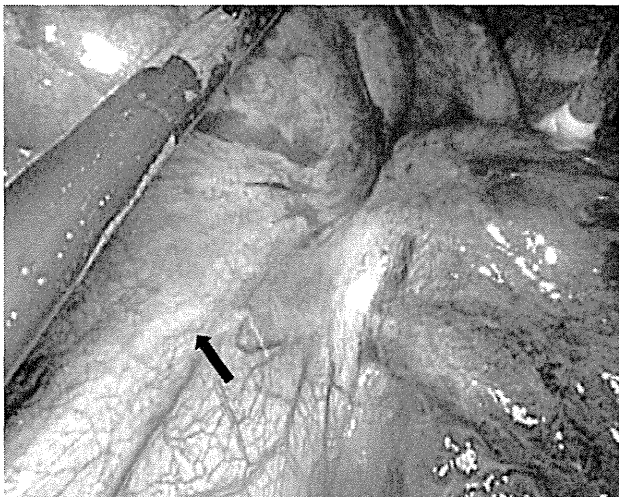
(A) Preoperative chest roentgenogram showed abnormal shadow on the left side of the mediastinum (arrow). (B) Preoperative chest roentgenogram taken after severe chest pain showing change in shape of an abnormal mass (arrow). (C) Thoracoscopic view showing thickened pleura and involvement of the phrenic nerve by the tumour (arrow). (D) Thoracoscopic view showing dense adhesions between tumour wall and pericardium (arrow).
